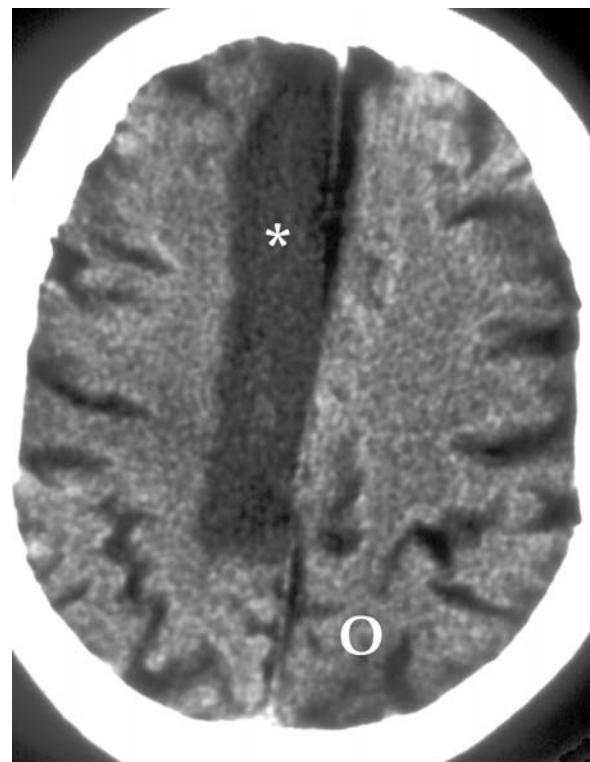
A CT scan showing a patient with an acute anterior cerebral artery infarct (*homogeneous gray area with asterisk*). The region of ischemia extends from the frontal lobe through the parietal lobe. Note that the occipital lobe (O) is spared as its blood supply comes from the posterior cerebral artery.
